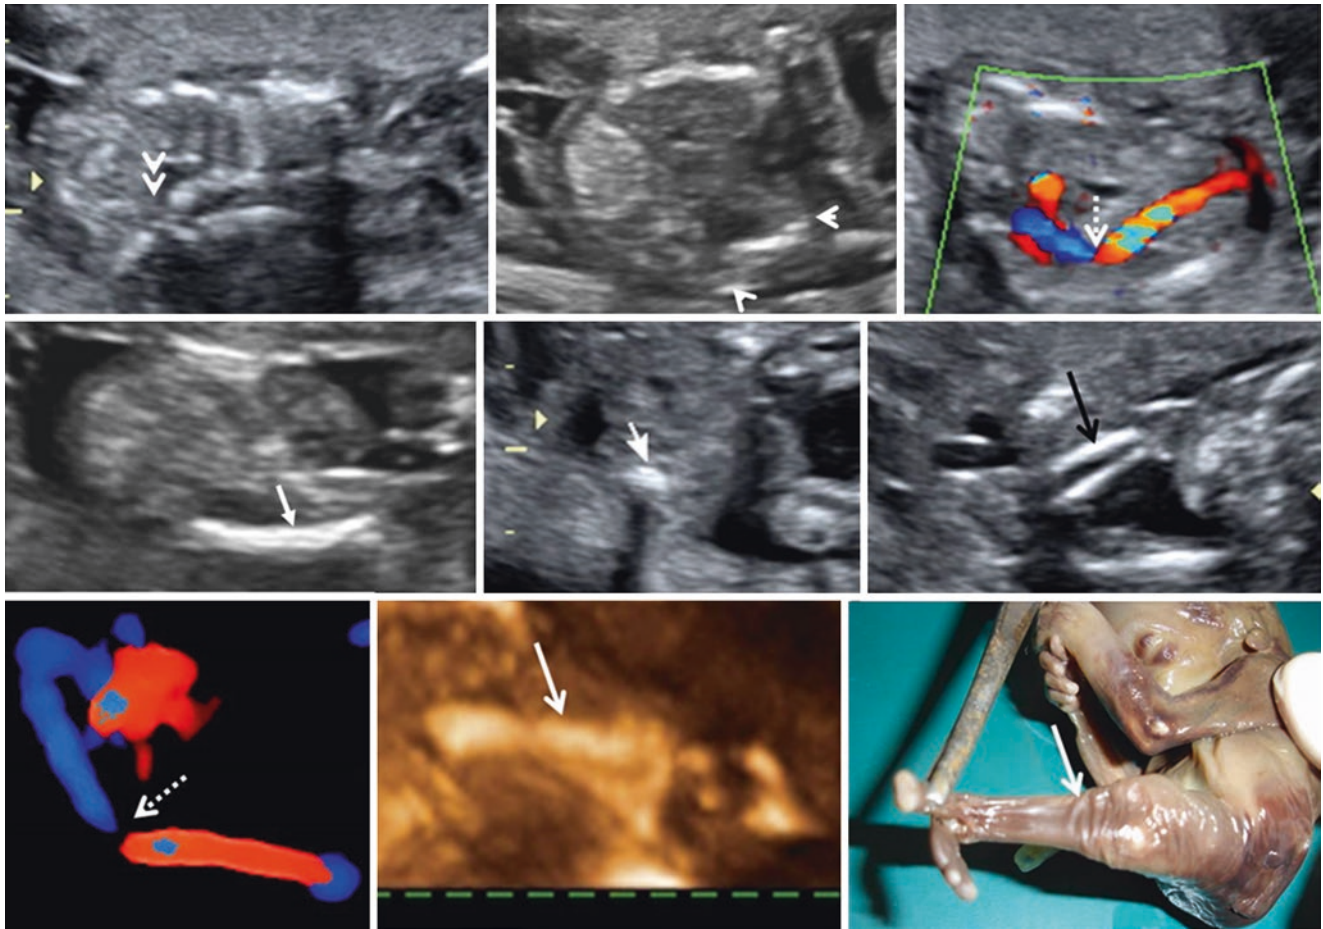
16 weeks (TAS) *sirenomelia sequence* – coronal section of the spine, axial section through the renal fossa, color Doppler of the abdominal aorta, femur longitudinal and axial sections, coronal section of the leg – total sacral agenesis resulting in the truncated spine (double arrowhead), both kidneys are not seen in their anatomical location
